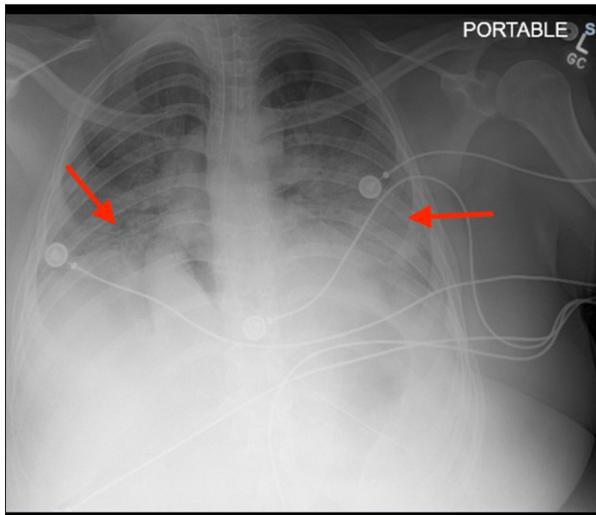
Chest X-ray on admission shows diffuse bilateral infiltrates (arrows).
